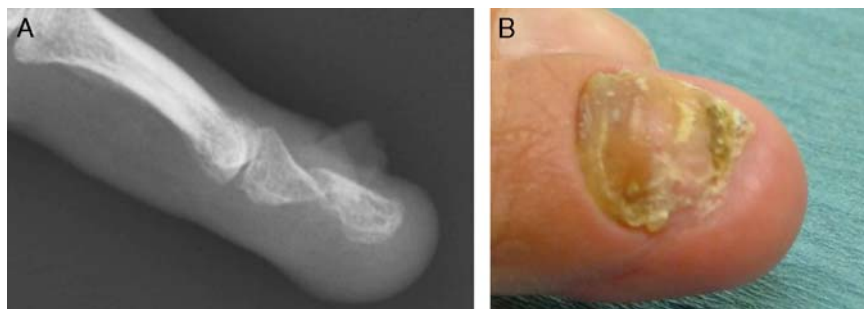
X-ray of a clinical case of a painful nonunion of the distal phalanx (A) and clinical picture with nail deformity (B). full color
